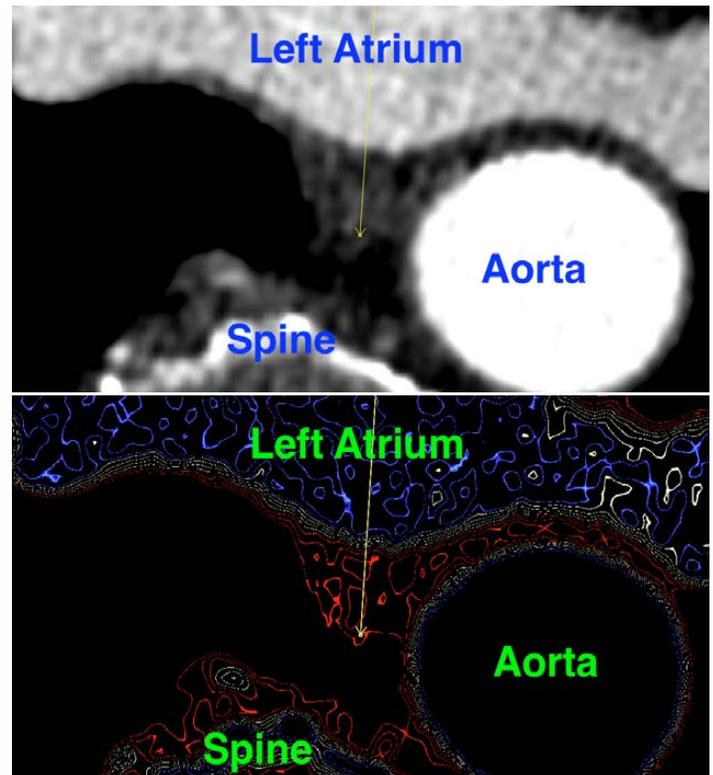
Cardiac CT with arrow marking measurement location/direction. (Above) *Traditional* method: intensity image. (Below) *Enhanced visualization* method: iso-Hounsfield unit contours.
